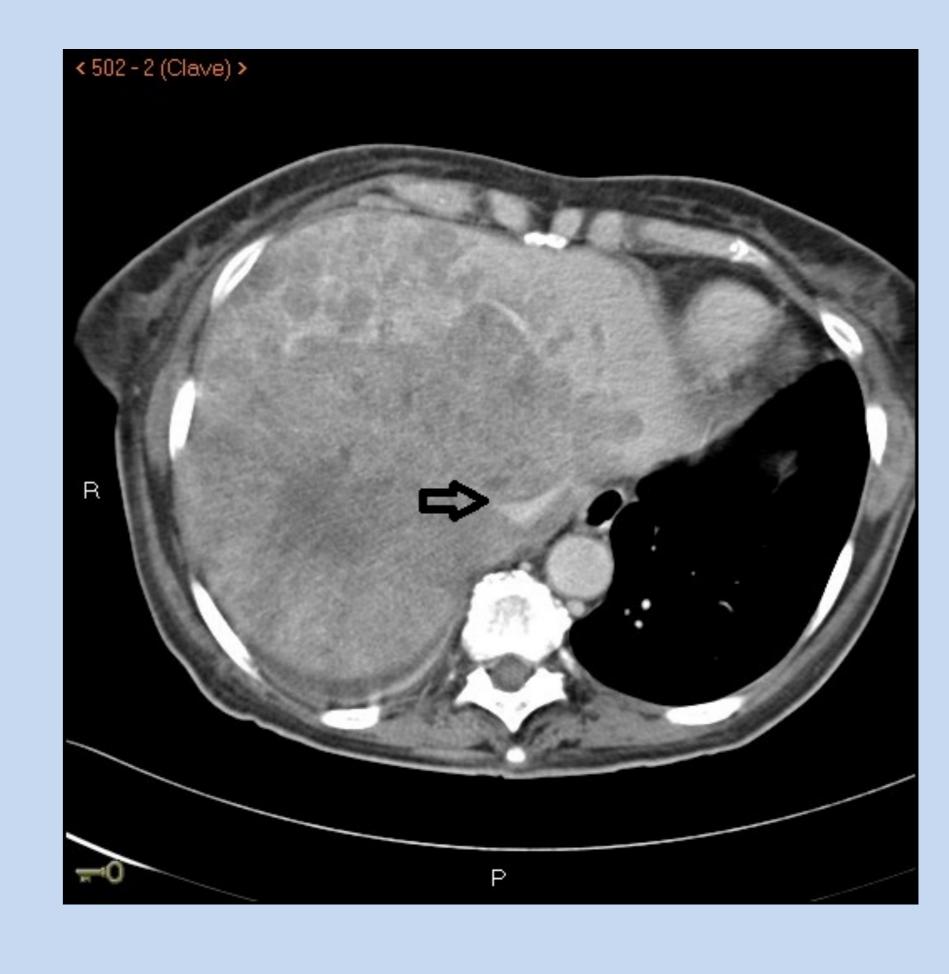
Compression of inferior vena cava (arrow) in high-resolution CT scan.
